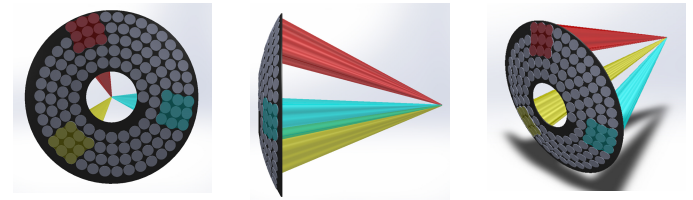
Three sub-array “clusters” of elements in the 128-element HIFU were used to transmit and receive imaging ultrasound pulses for motion measurement. These clusters have acoustic directions that are sufficiently linearly independence to provide 3D displacement information.
